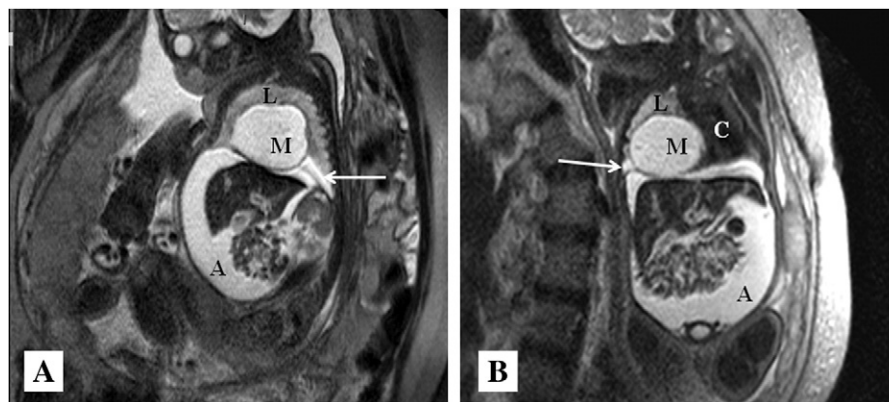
Sagittal (A) and coronal (B) ultrafast magnetic resonance imaging images at 36 weeks of gestation showing a fetal lung mass (M) in the setting of cardiac compression (C), pleural effusion (arrow), and ascites (A) compressing the lung (L) and everting the diaphragm into the abdomen.
